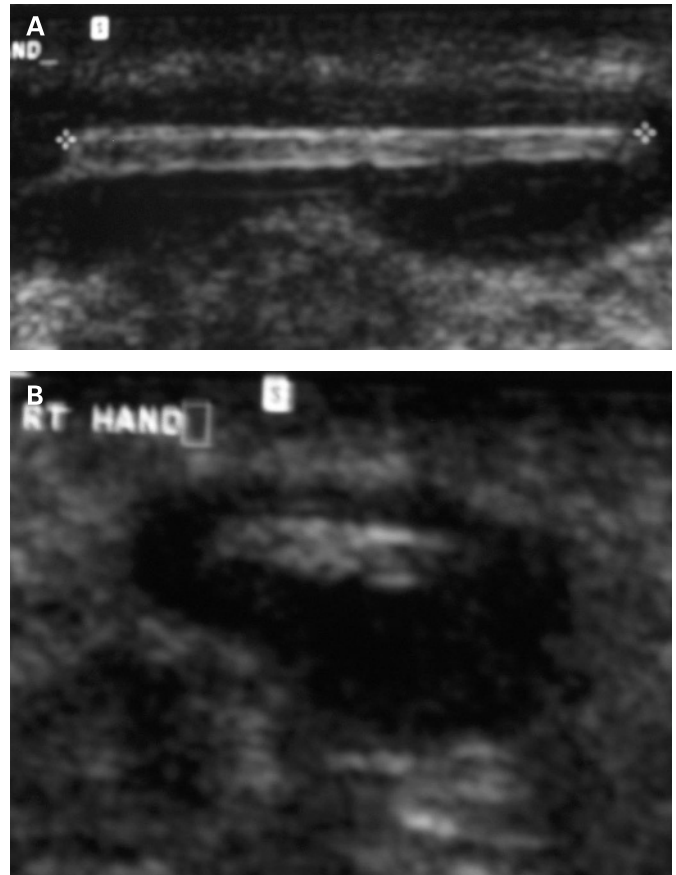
(A) Longitudinal and (B) transverse ultrasound images clearly showing a wooden splinter with associated foreign body reaction.
